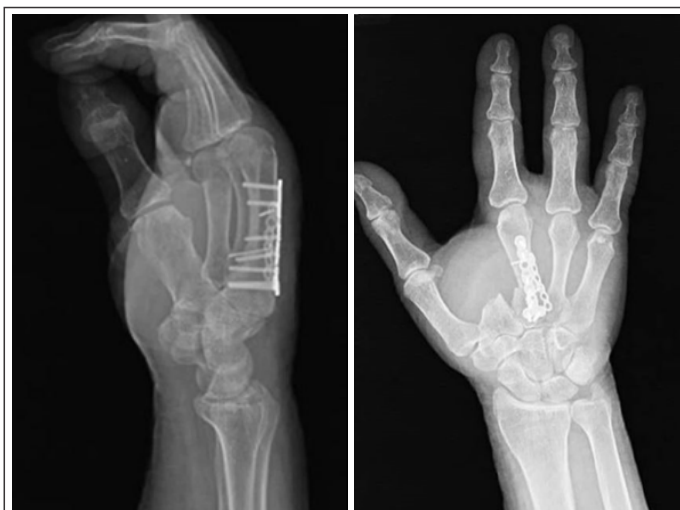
Initial 2-week follow-up X-rays.
